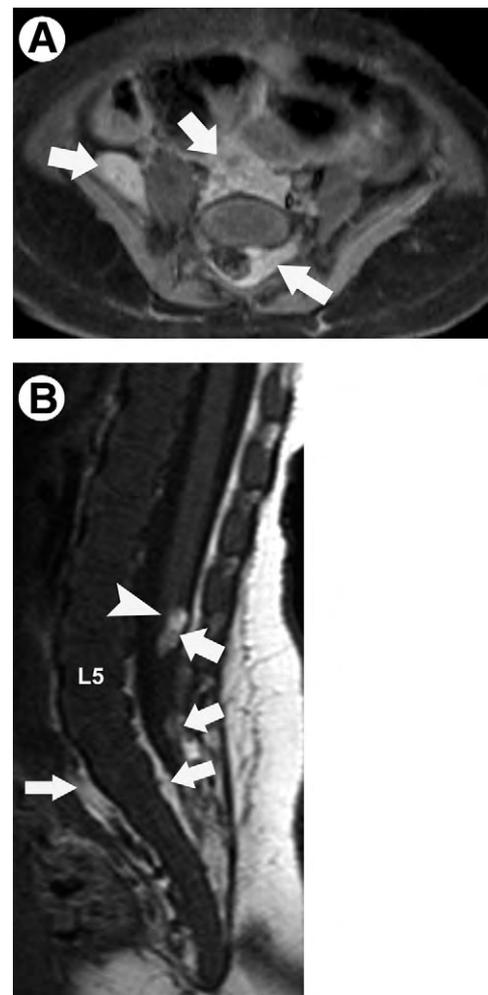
LUMBAR regional syndrome in a 4-week-old female patient with extensive cutaneous hemangiomas on the lower abdomen and legs, left renal agenesis, and a patent urachus. T1-weighted contrast-enhanced (A) axial and (B) sagittal fat-suppressed magnetic resonance (MR) images demonstrate multiple enhancing well-defined lobular masses consistent with hemangiomas (arrows). Abnormally low conus position (arrowhead) is also shown. L5-Fifth lumbar vertebra.
